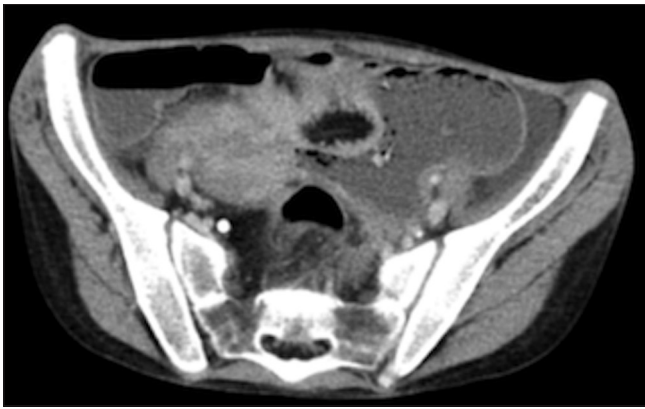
CT scan of a terminal ileum thickness
